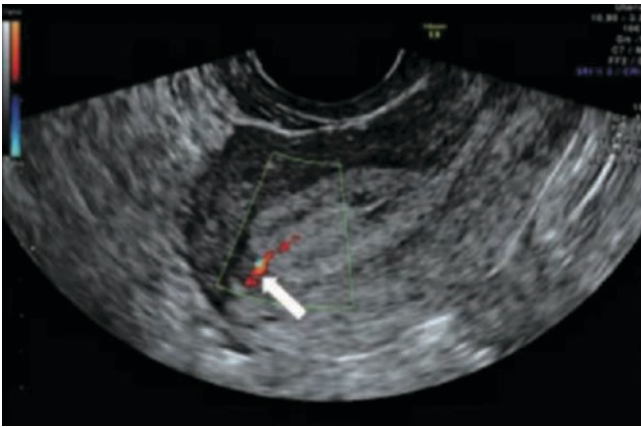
Color Doppler shows the blood vessels supplying the endometrial polyp (arrow)
